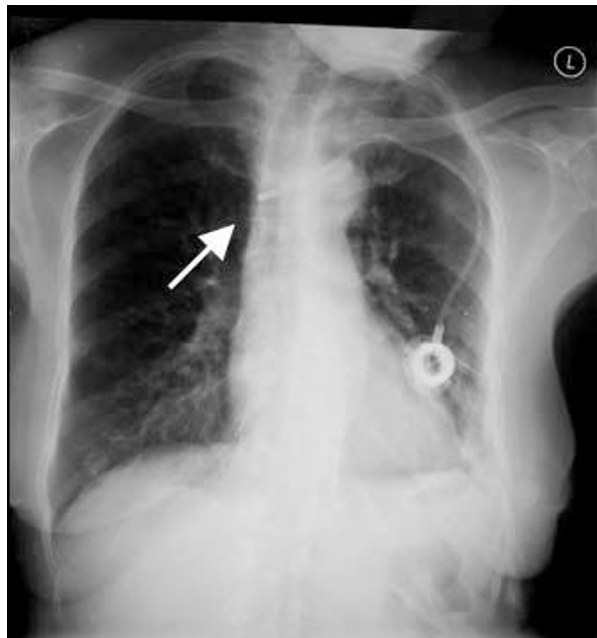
64-year-old woman with implanted venous access device. Chest radiograph shows malpositioning of the catheter tip.
